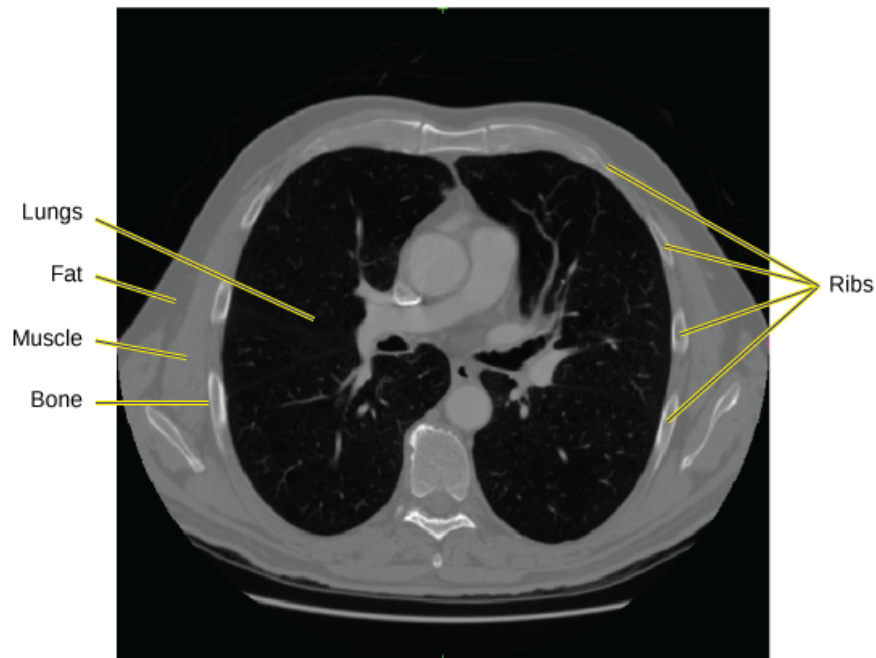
Example axial CT slice through the chest. Image intensity indicates tissue radiodensity, and ribs are seen in oblique cross-section as they pass through the axial plane.
